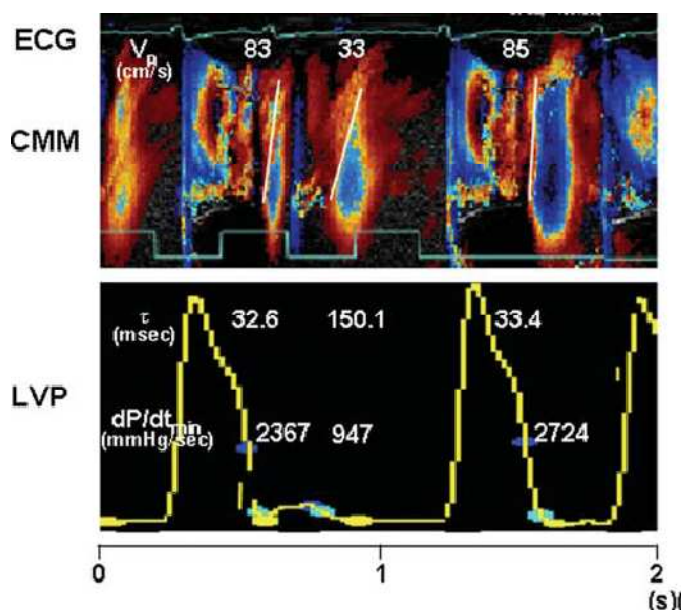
M - mode color Doppler for the mitral inflow (43)
